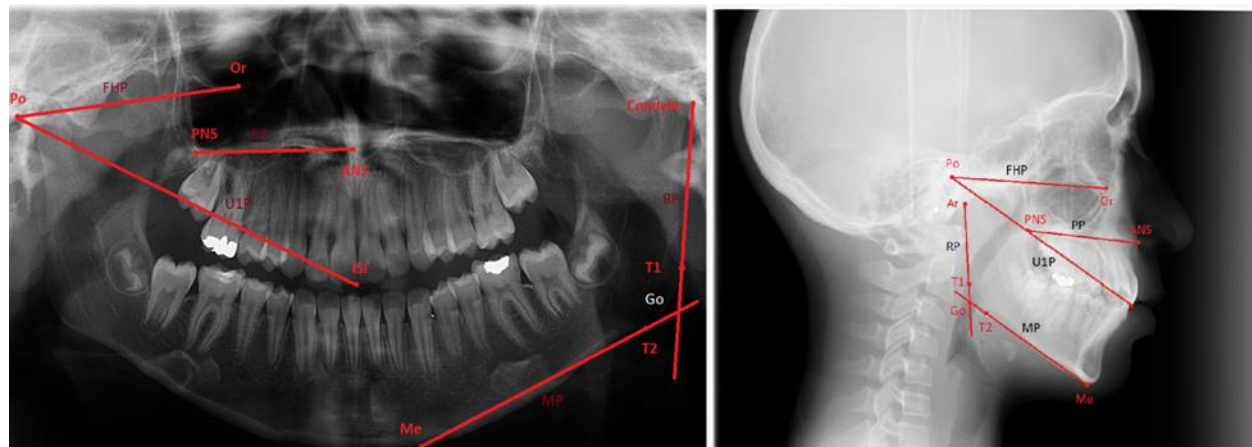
An example of the lines and planes used for angular measurements on panoramic (Left) and lateral cephalometric (Right) radiographs of a patient. ANS: Anterior nasal spine; Ar: Articulare; FHP: Frankfort horizontal plane; Go: Gonial angle; ISI: Incision superius incisalis; Me: Menton; MP: Mandibular plane; Or: Orbitale; PNS: Posterior nasal spine; Po: Porion; PP: Palatal plane; RP: Ramus plane; U1P: Upper incisor plane.
